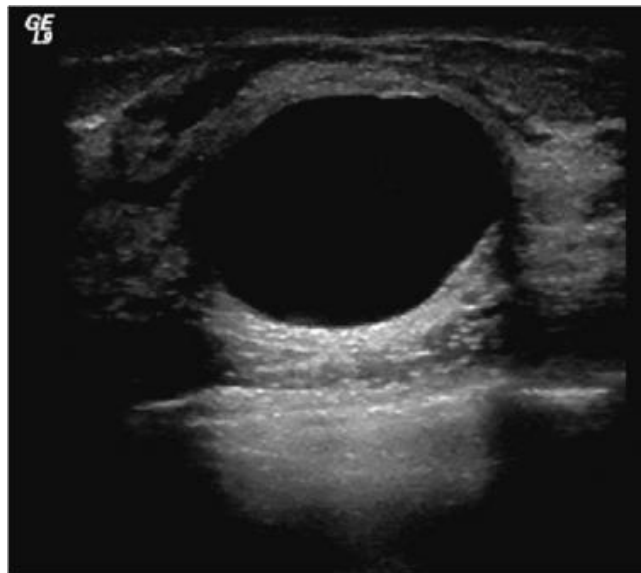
Ultrasound shows an anechoic cyst with smooth margins and enhanced through transmission. This is benign and does not need any imaging follow-up.
